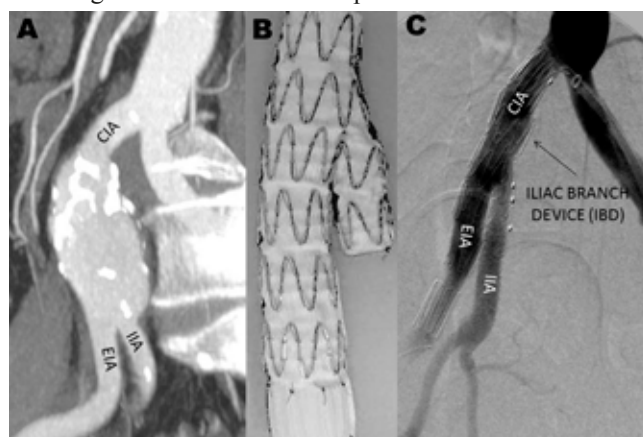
Iliac branched devices (IBD) are an option for treating an isolated CIA aneurysm or an aorto-iliac aneurysm avoiding the need for deliberate occlusion of the IIA. Image A, a CT maximum intensity projection (MIP) demonstrating an isolated CIA aneurysm. Image B shows an in vitro deployed IBD. Image C, post-procedural angiogram of an isolated CIA aneurysm (same case as image A) successfully treated with an IBD.
